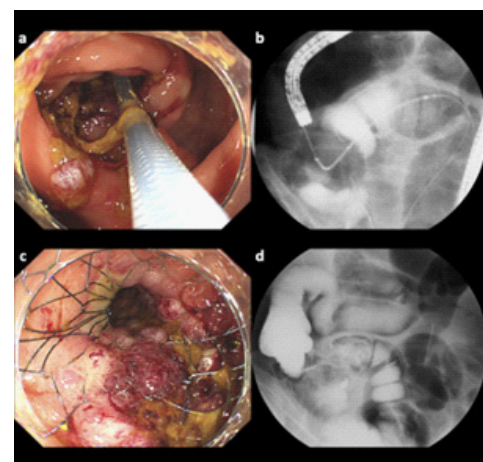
During stent placement, the angle from the ileocecal valve to the ileum was so steep that the endoscope moved away (a). X-ray imaging in an oblique position (b). Immediately after stent placement for ileocecal valve dilation (c). Retrograde gastrografi-nography from the anal side of the stent confirmed that the stent dilation released the ileocecal stenosis (d).
